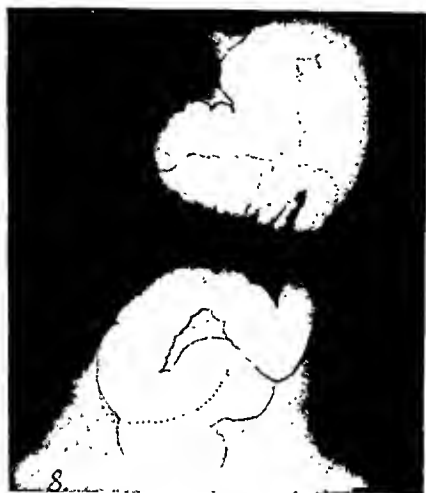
X-ray projection of authors' case. Sinistrotocolia of second degree with normal rotation.
